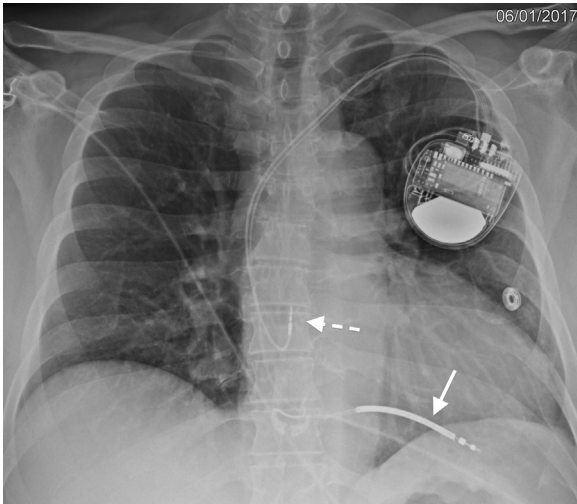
Chest radiograph demonstrating an implantable cardioverter defibrillator. A dual-chamber device with 1 lead in the right atrium (dashed arrow) and another in the right ventricle (solid arrow). A defibrillation coil is present (solid arrow), which differentiates it as an implantable cardioverter defibrillator.
